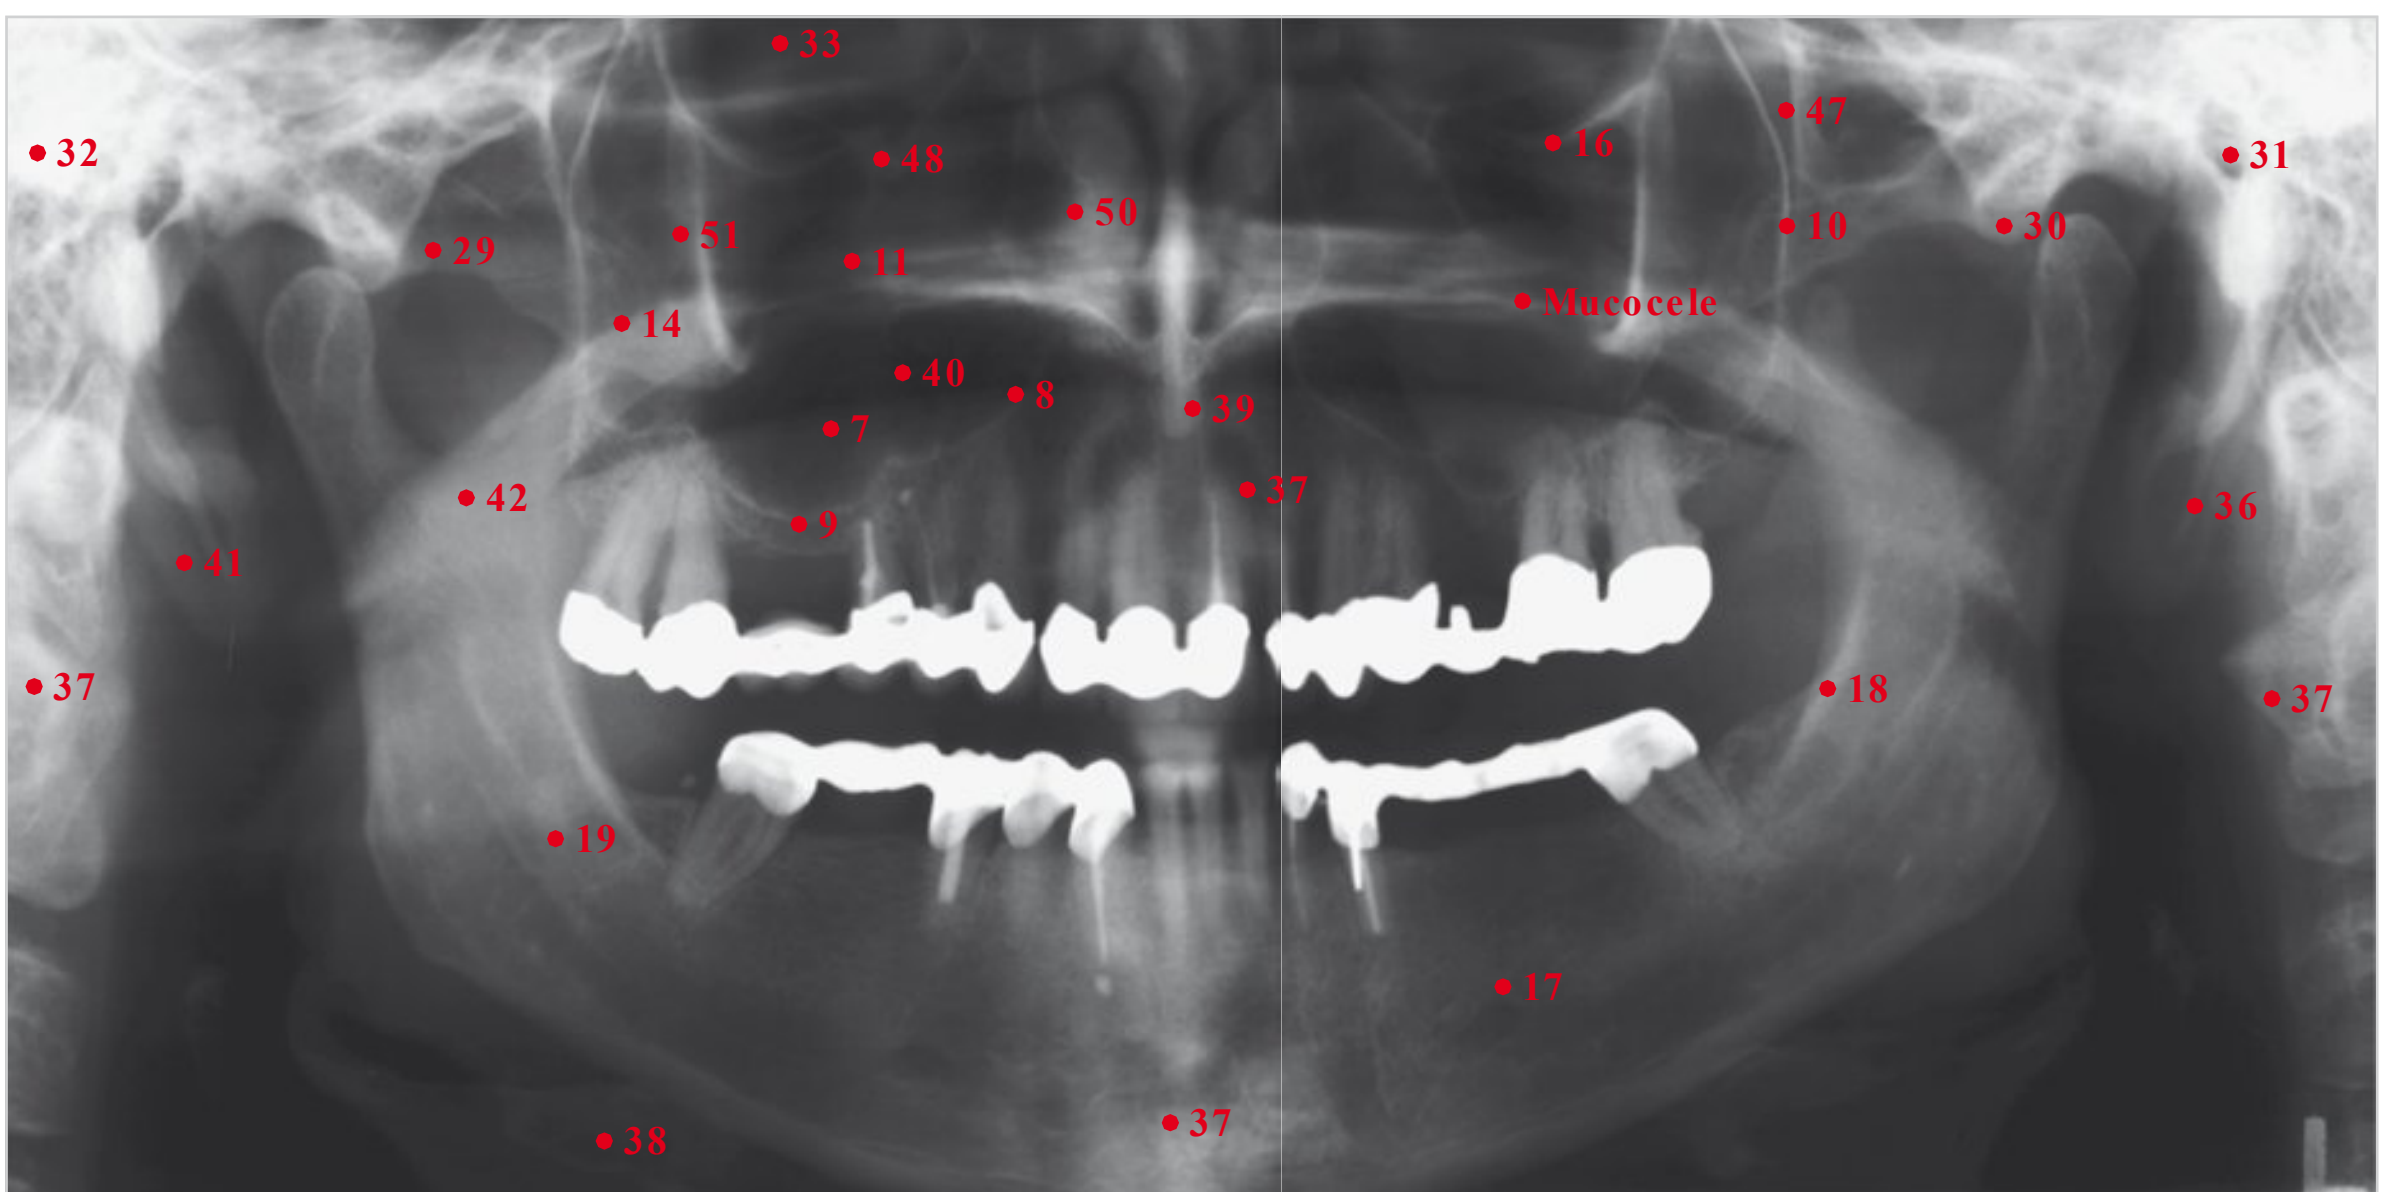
Panoramic radiographic anatomy of the mandibular and maxillary region. See □ Table 9.1 for key to numbers.
